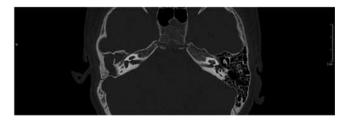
Pre-operative temporal bone CT scan of case 1.
